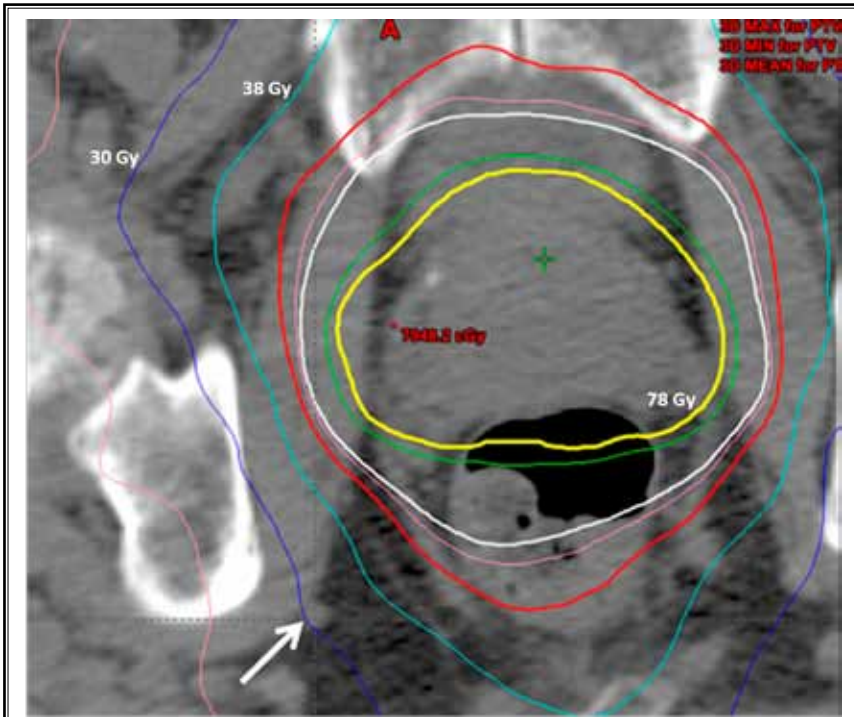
Dose distribution projected on axial CT image. The pudendal nerve (arrow) received between 30 and 38 Gy (represented by the dark and light blue lines, respectively). The prostate received a dose of at least 78 Gy (yellow line).
